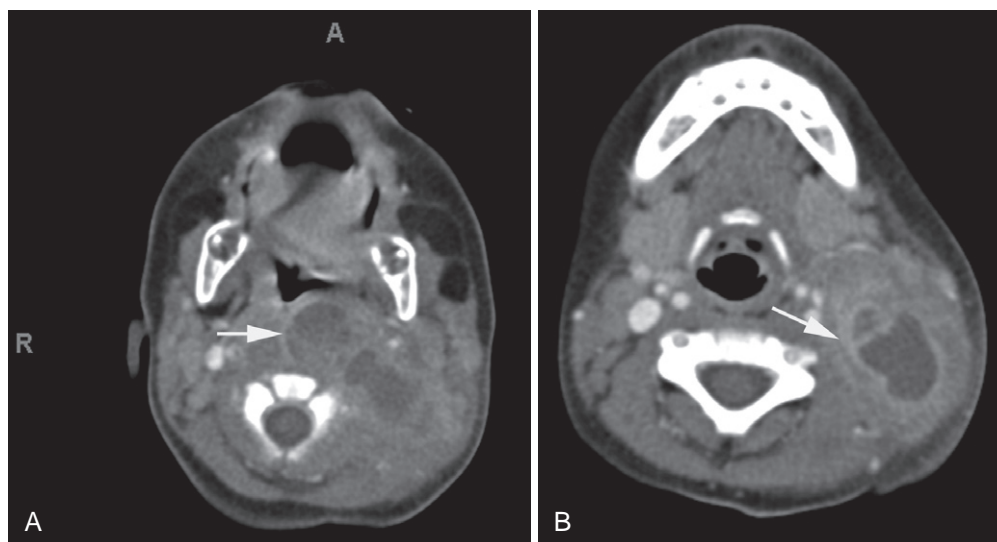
A, Retropharyngeal abscess. Computed tomography of the cervical area demonstrates fluid loculated in the retropharyngeal space. The abscess is typically unilateral and frequently extends into the medial aspect of the parapharyngeal space. In the absence of associated complications, drainage can be done intraorally (arrow). B, Lateral neck abscess on the left side (arrow).
